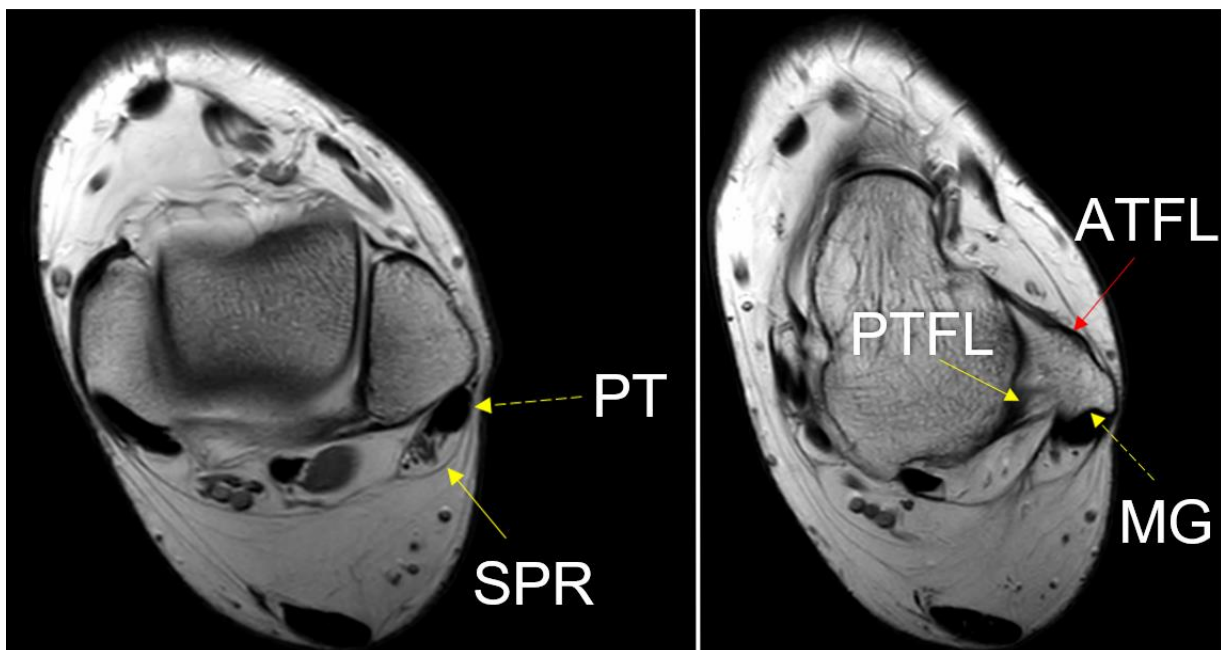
Structures on normal ankle MRI. PT=Peroneal tendons. Note how the brevis and longus are not discernable from each other. SPR=Superior peroneal retinaculum. ATFL=Anterior talofibular ligament. PTFL=Posterior talofibular ligament. MG=Malleolar groove. The shape is concave in this case.
